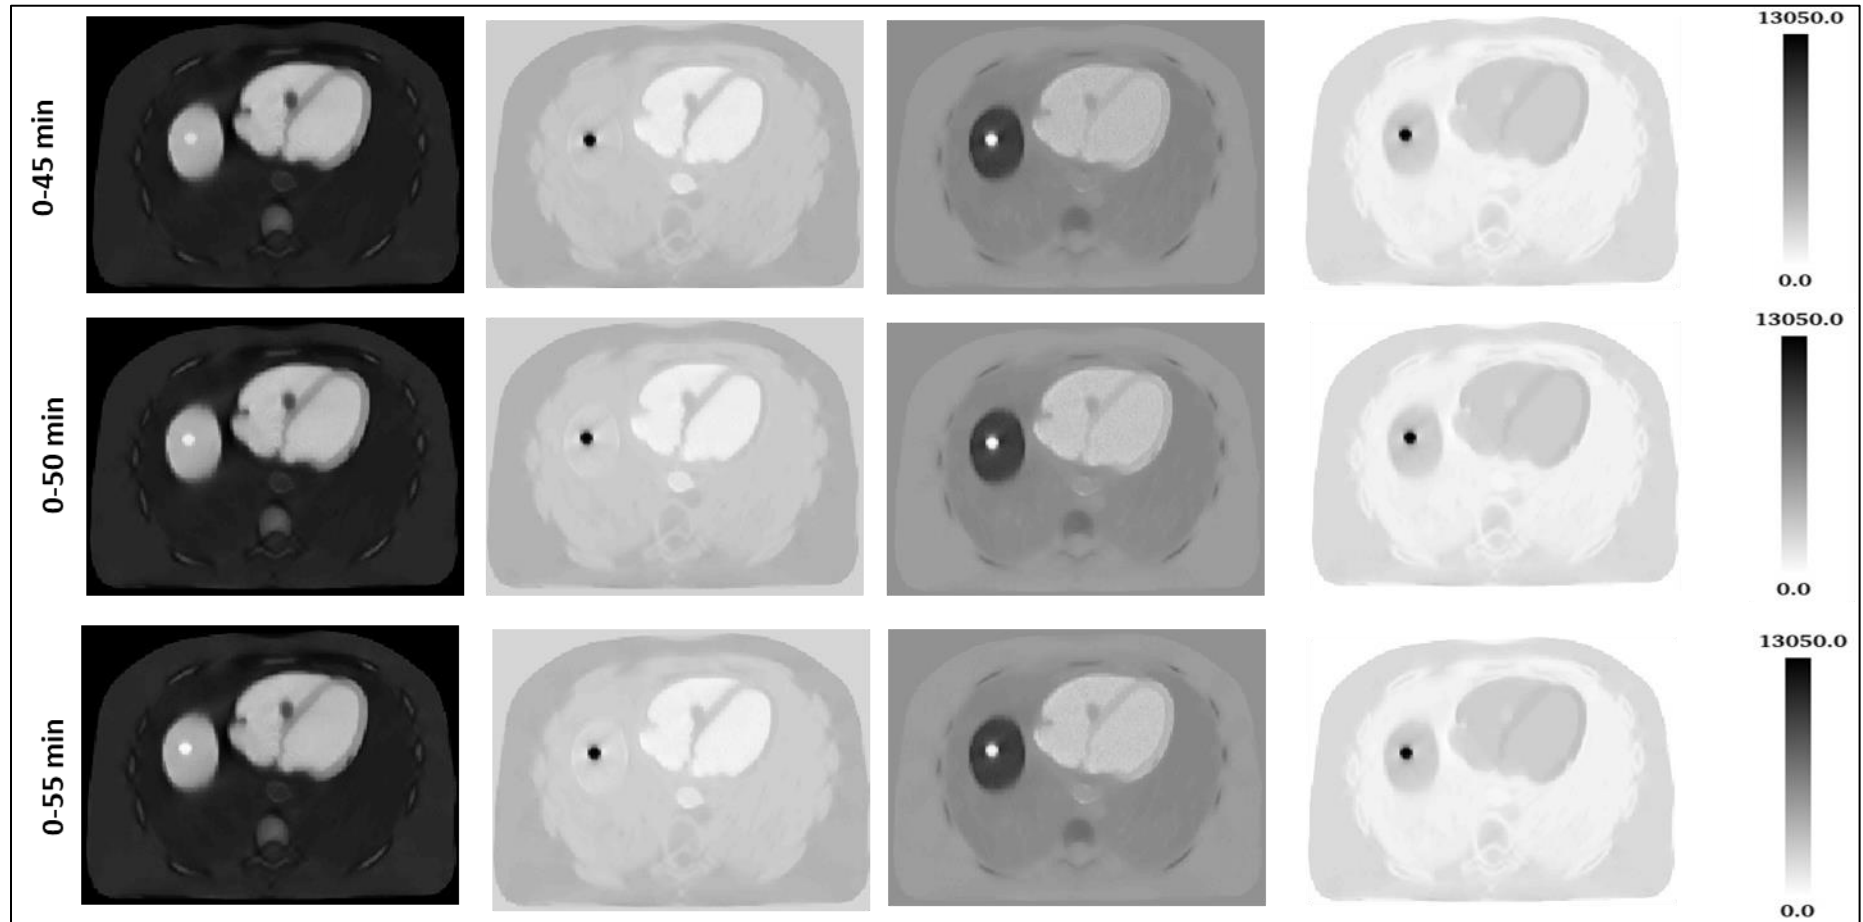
c Transverse slices obtained by the PCA method at 0-45, 0-50 and 0-55 time intervals showing ^{18}F -FDG uptake in lesions and other tissues. The SUM images were generated at 35-55 min intervals as described above.
